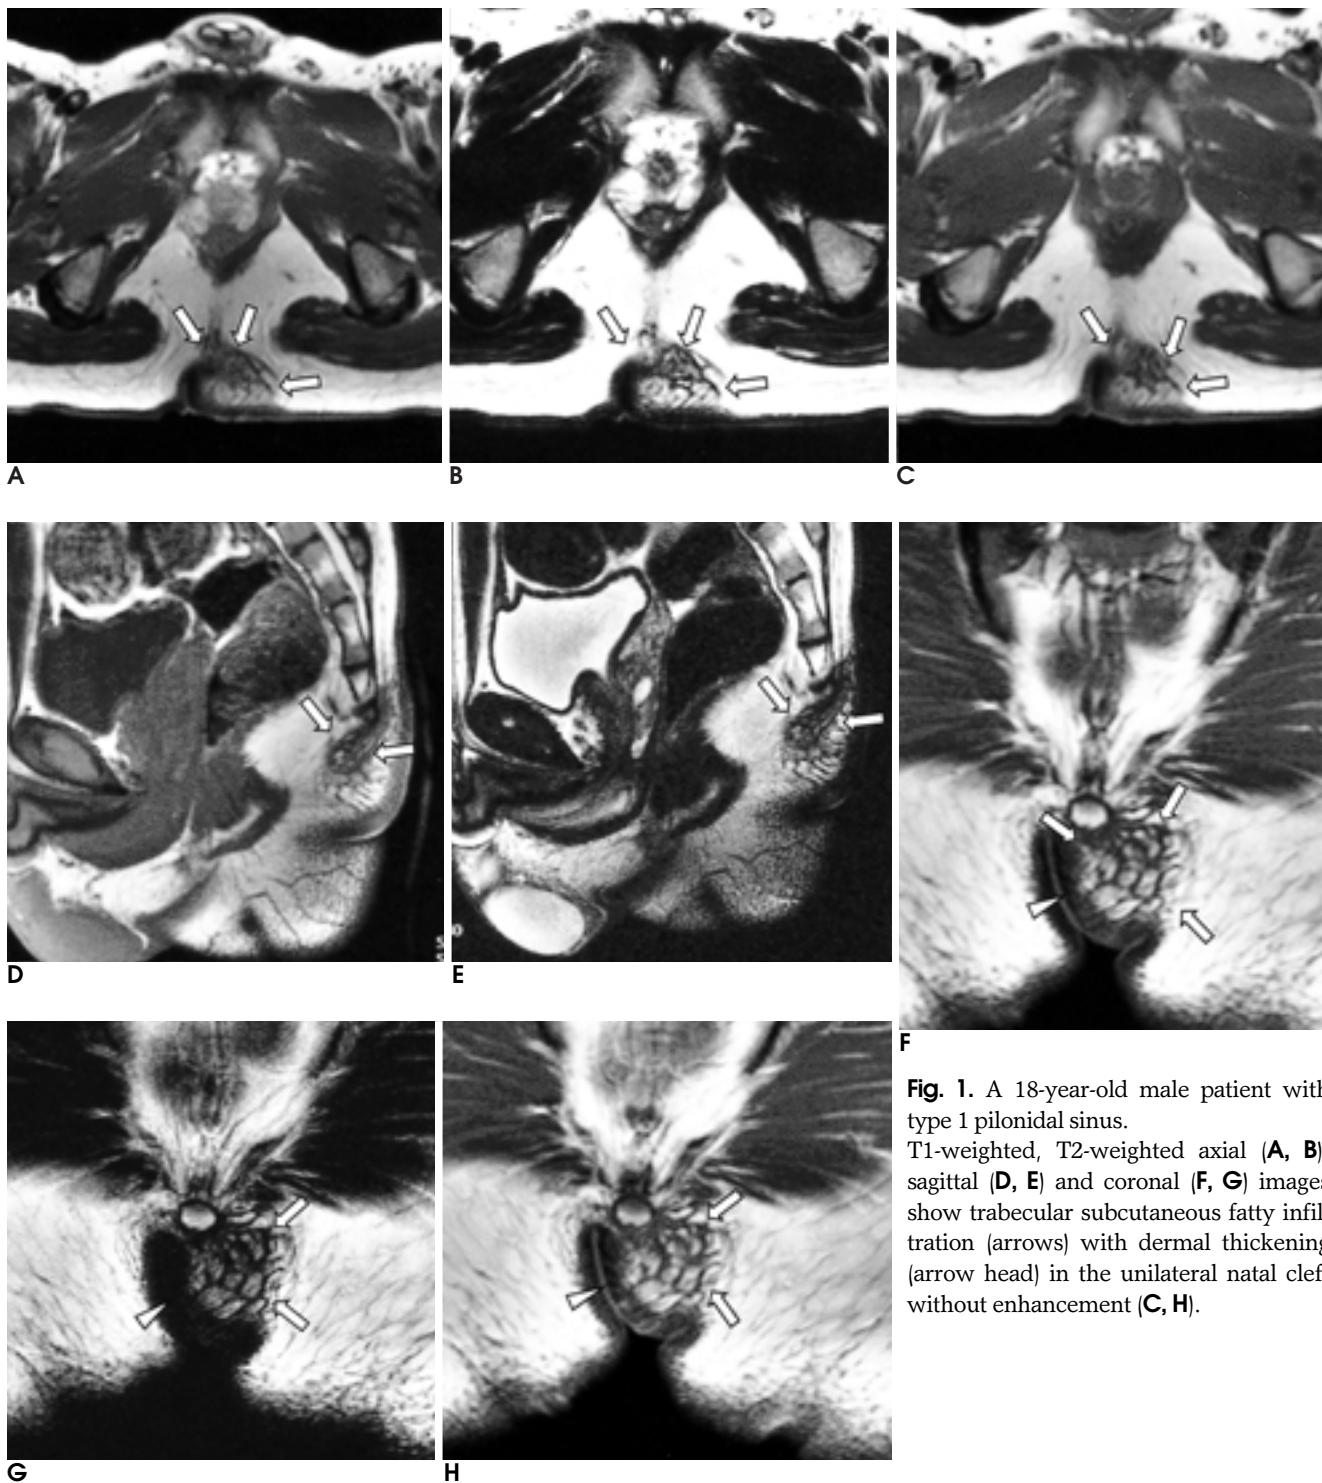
A 18-year-old male patient with type 1 pilonidal sinus. T1-weighted, T2-weighted axial (A, B), sagittal (D, E) and coronal (F, G) images show trabecular subcutaneous fatty infiltration (arrows) with dermal thickening (arrow head) in the unilateral natal cleft without enhancement (C, H).
